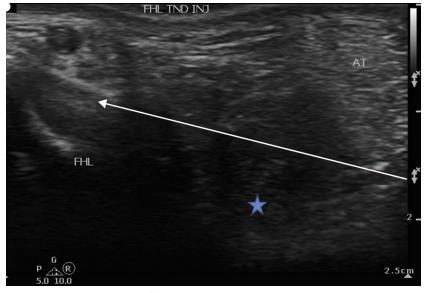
Sonographically guided flexor hallucis longus tendon sheath injection, short axis to the FHL tendon and Achilles tendon (AT), needle approach in plane with transducer. Arrow delineates path of needle. Star, Kager fat pad. Left, medial; right, lateral.
